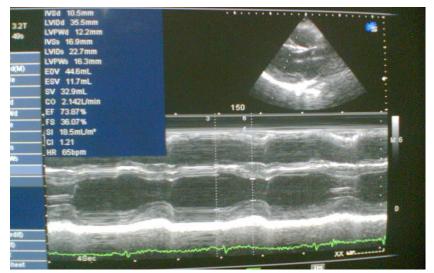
2D/M echocardiogram of 39 year old female subject with keloid
